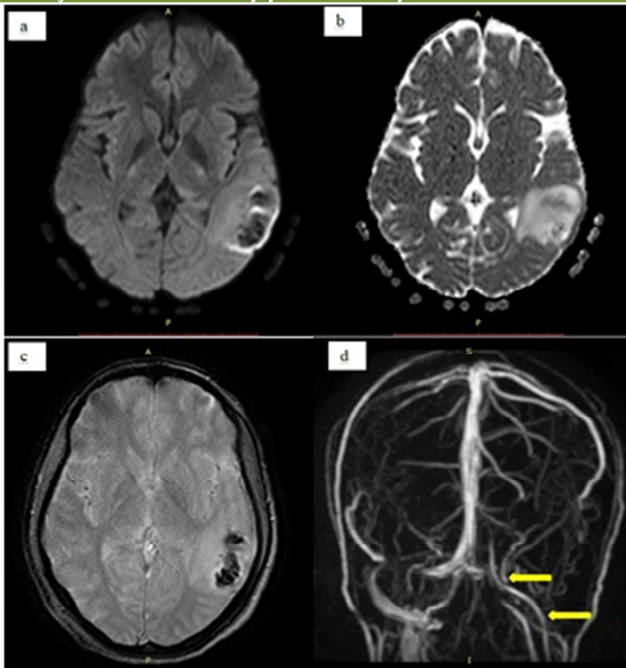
Adult male presented with headache and weakness showing altered signal intensity on DWI(a) and ADC(b) with no true restriction and shows areas of blooming on gradient sequence(c) in left temporal lobe. TOF MRV(d) showing thrombosis of left transverse, left sigmoid and left internal jugular veins.
